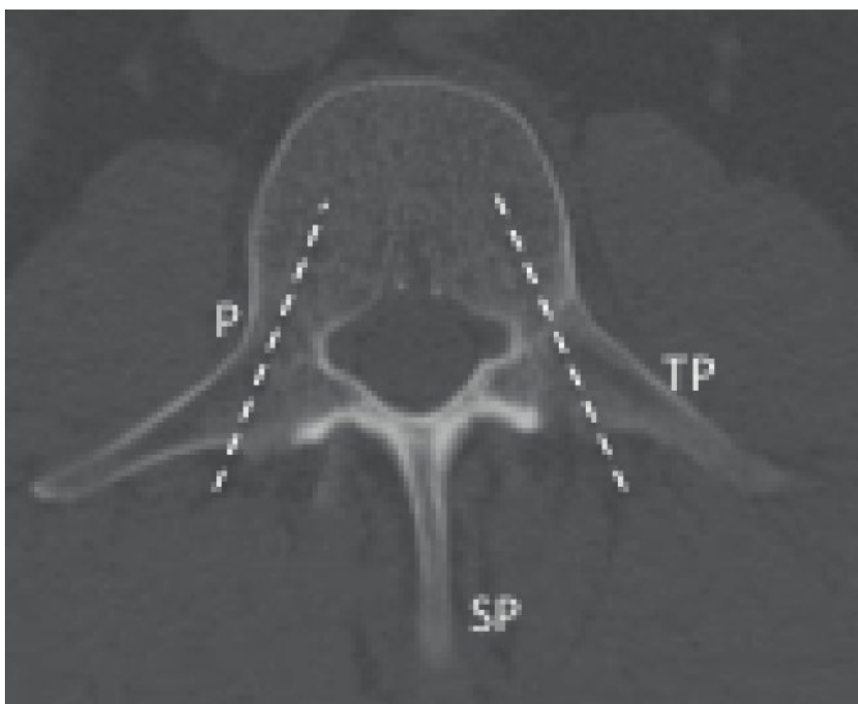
Lumbar spine (axial computed tomography at L3). P, pedicle; SP, spinous process; TP, transverse process; dotted lines, trajectory for spinal access needles and pedicle screws.
